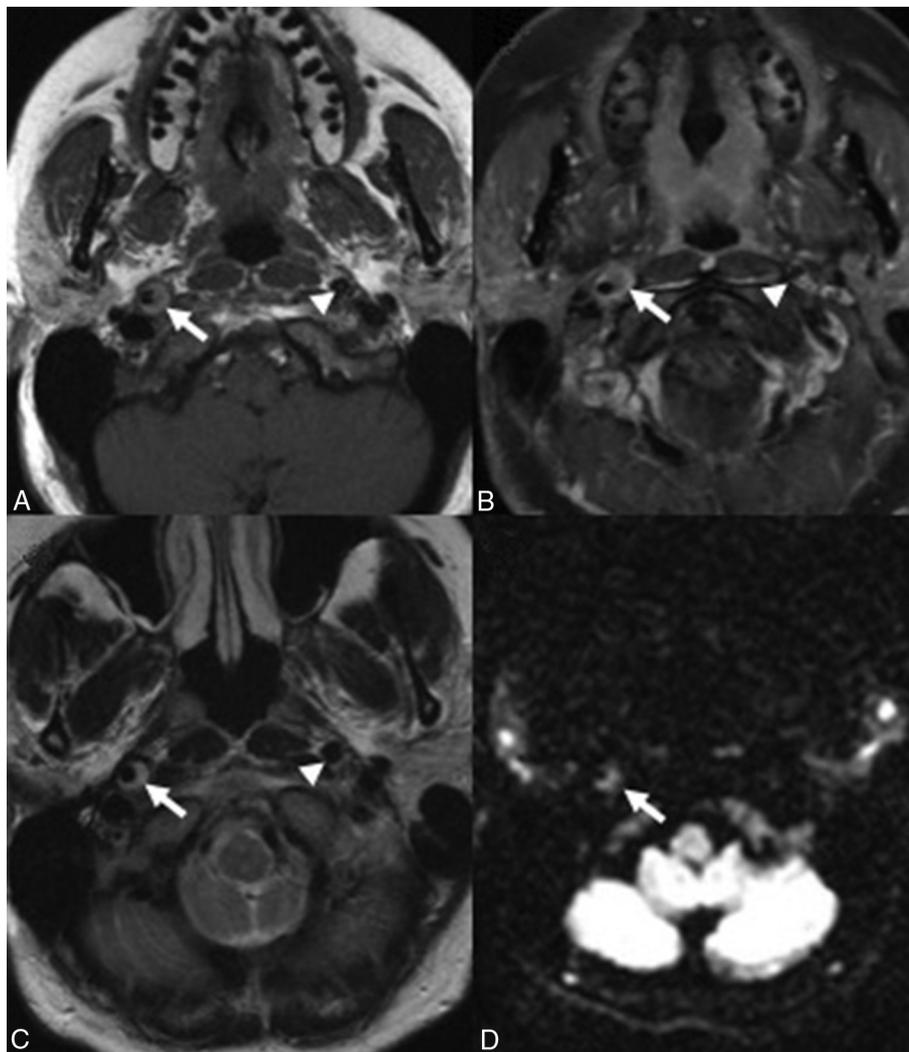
Right carotid artery dissection (arrow) on axial, magnetic resonance imaging (MRI) of the brain. The left carotid artery (arrowhead) is patent. A) T1-weighted, fast-spin echo without contrast. B) T1-weighted, fat-suppressed with gadolinium. C) T2-weighted, fast-spin echo. D) Diffusion-weighted imaging shows restricted diffusion, seen as high signal, at the right carotid.
